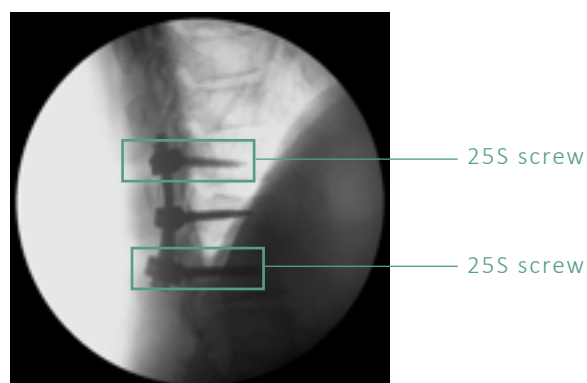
Lateral immediate post-operative X-ray
